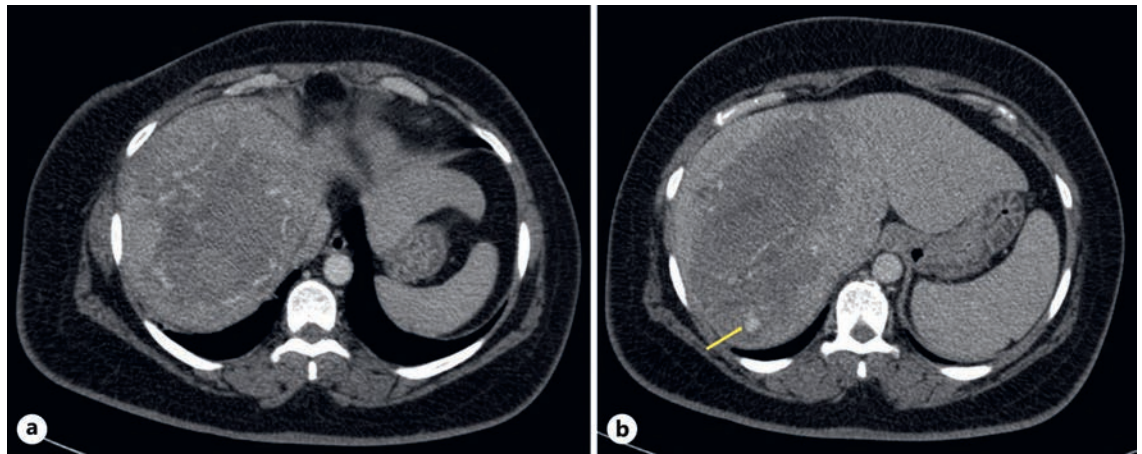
Abdominal contrast-enhanced CT. a A $10 \times 21 \times 20$ cm tumor of uncertain etiology in the right liver lobe with intratumoral spontaneously hyperdense foci suggestive of blood products. b Active bleeding (arrow) in the early arterial phase in segment VII.
